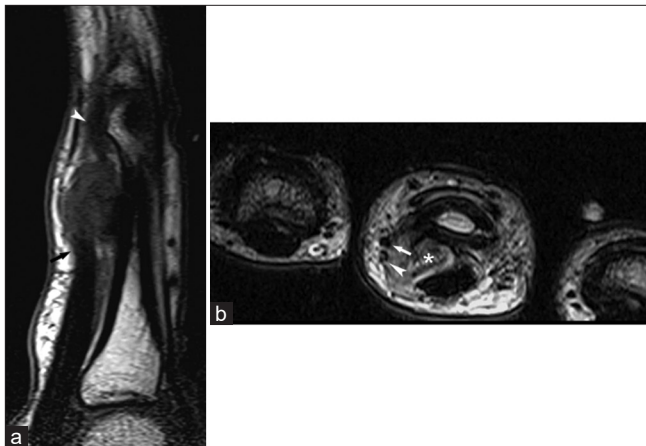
(a) Sagittal T1-weighted MR image of the middle finger shows the bone surface mass abutting the flexor tendons (arrow) and the volar plate (arrowhead). (b) Axial T2-weighted MR image of the third digit at the level of the proximal second to fourth phalanges shows the juxtacortical mass (asterisk) interposed between the phalanx and the deformed tendon. Note the adjacent digital artery (arrow) and nerve (arrowhead). MR: Magnetic resonance
